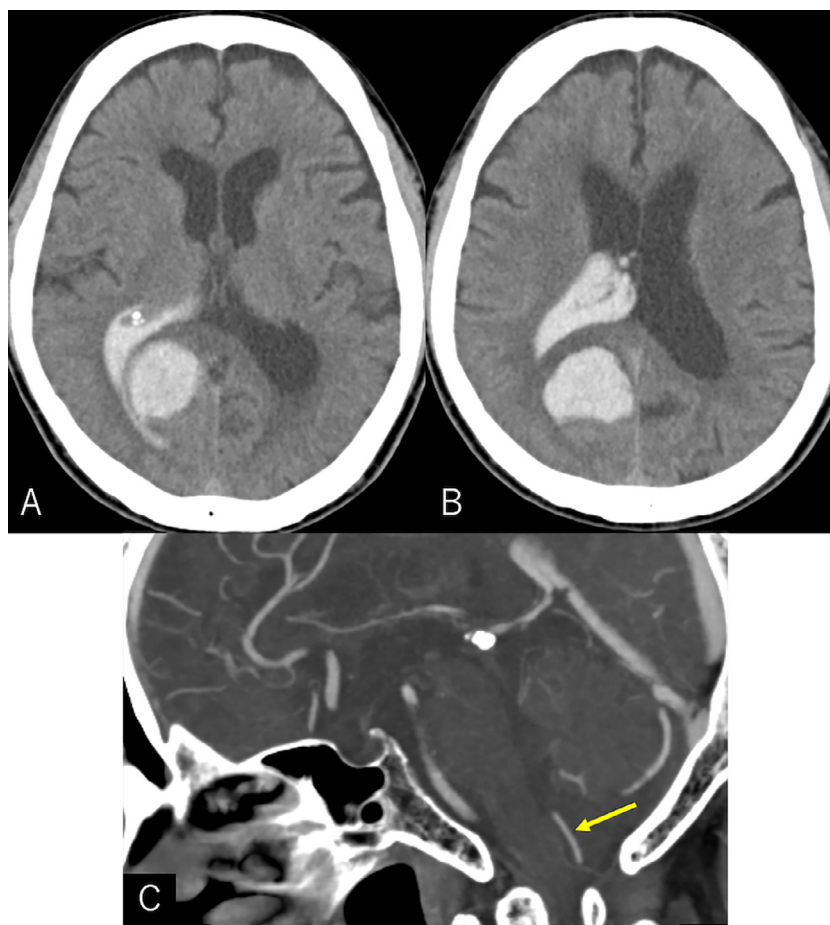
Noncontrast axial computed tomography scans at the level of the foramen of Monro (A) and body of the lateral ventricle (B), performed at the initial presentation, depict a 33 × 24 × 43 mm intracerebral hemorrhage in the right occipital lobe, accompanied by ventricular perforation. (C) Contrast-enhanced sagittal computed tomography scan reveals no abnormal findings around the brainstem (arrow).
